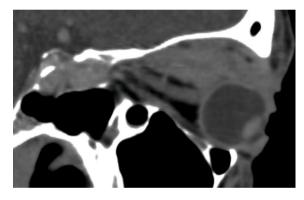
Sagittal CT image showing adenocarcinoma of the lacrimal gland with widespread pervasion of the orbit
